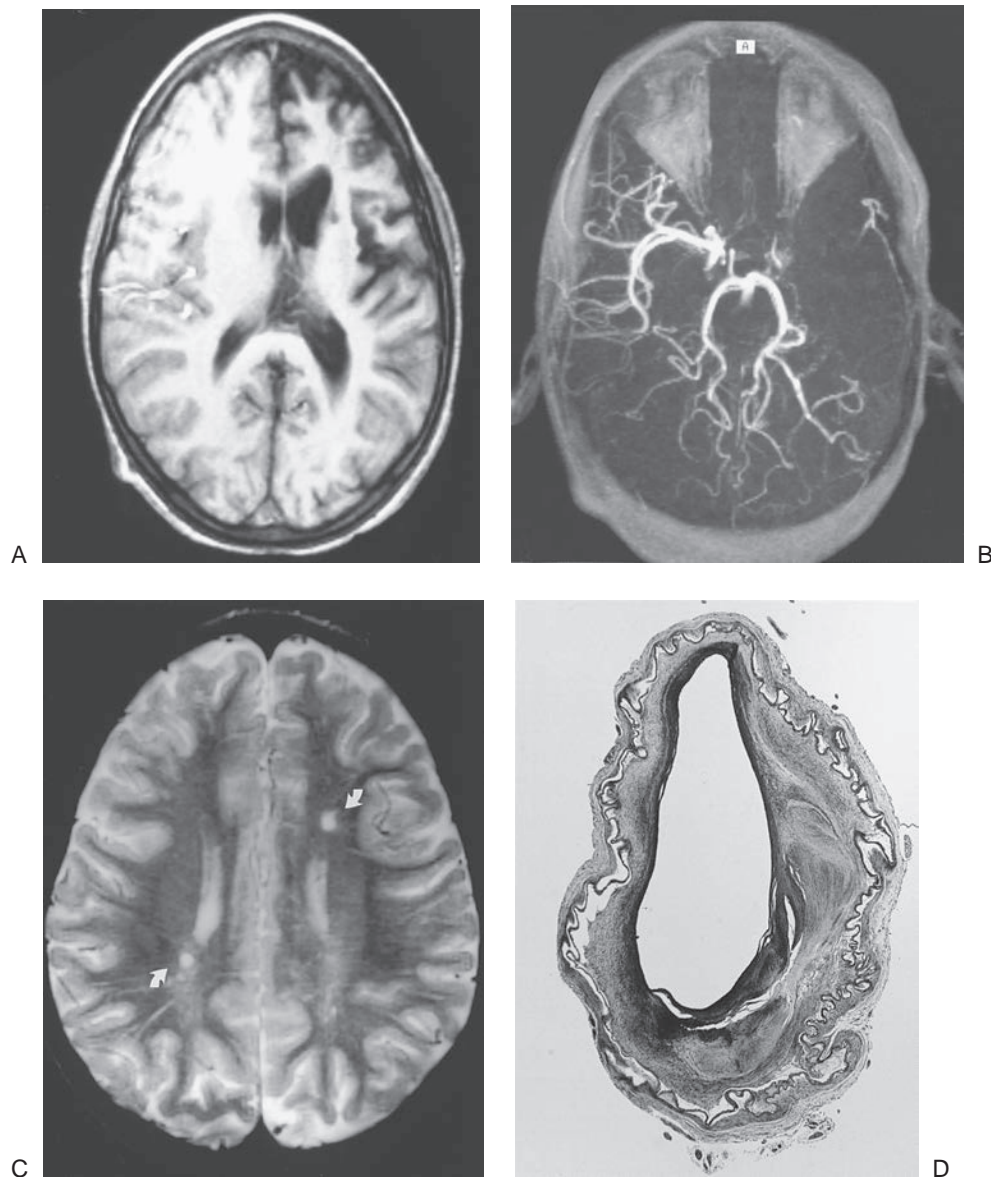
Vaso-occlusive effects in the central nervous system. A: T1-weighted magnetic resonance imaging (MRI) in a 6-year-old girl with hemoglobin (Hb) SS and a history of stroke. There is extensive atrophy involving the distributions of the left anterior and middle cerebral arteries with compensatory enlargement of the left lateral ventricle. B: Magnetic resonance angiography in the same patient showing occlusion of left middle cerebral artery and diminished flow through both anterior cerebral arteries. C: T2-weighted sagittal MRI in a 4-year-old boy with "silent infarcts." Small areas of leukomalacia are seen in deep white matter in frontal and parietal areas (arrows). D: Pathologic section of internal carotid artery showing fibrinous thrombus with parallel layers of fibrin deposited on intimal surfaces and atrophic media. Courtesy of Dr. J. J. Jenkins, St. Jude Children's Research Hospital.
